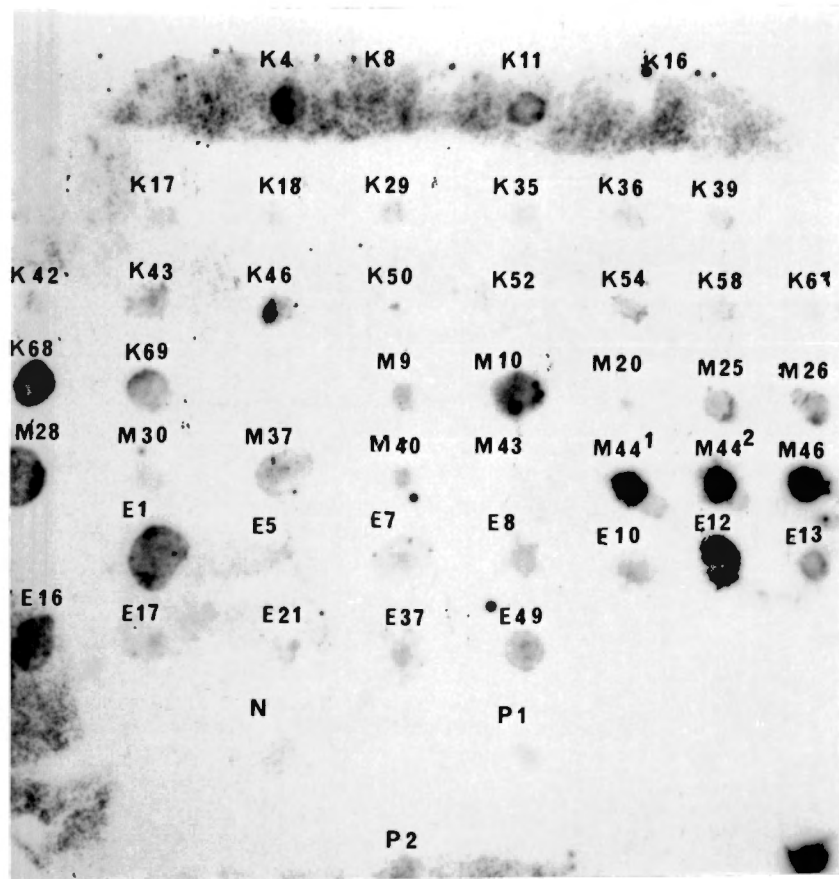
Hybridisation of PCR generated SHV probe to colony blot prepared by culturing colonies of the test isolates on agar, transferring the colonies to a nylon membrane and lysing the cells with NaOH. The membrane was exposed to X-ray film (Curix RPI, Agfa) for 1 hour.
